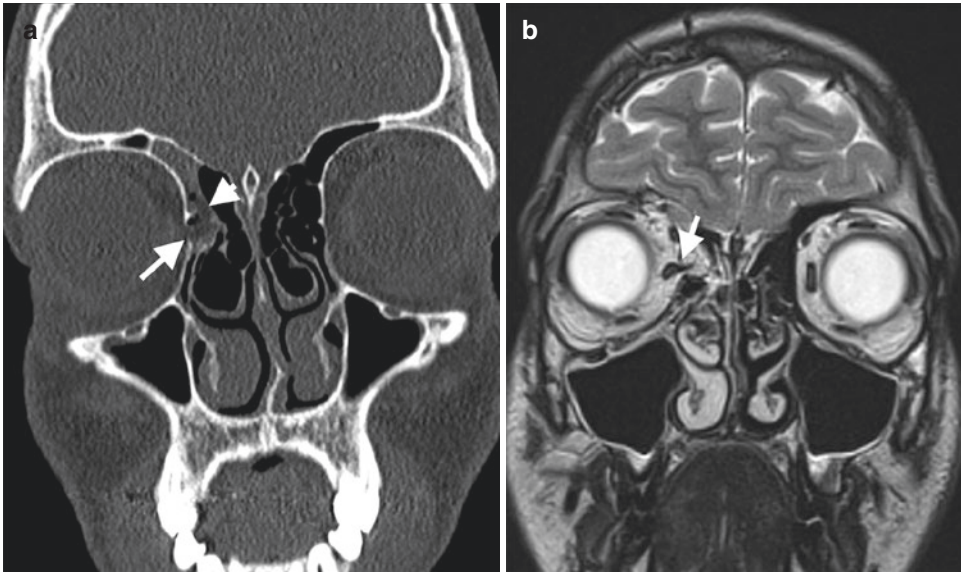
Blow-out fracture with entrapment of medial rectus muscle in a 14-year-old man with a history of assault. (a) Coronal CT image reveals a defect (arrow) in right medial orbital wall with fat herniation to the adjacent
